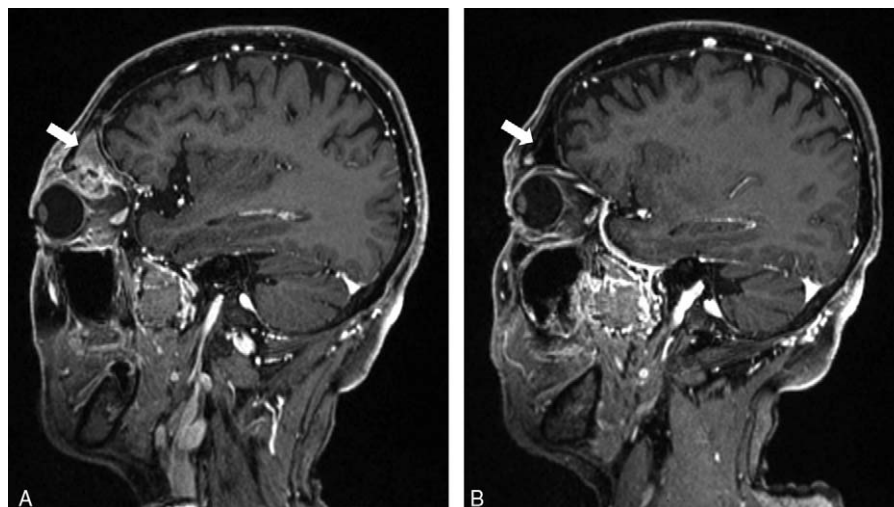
Magnetic resonance imaging of left ocular region before and after therapy. White arrows indicate the change of lesions. (A) Neoplasm and soft tissue mass in left frontal sinus before chemoradiotherapy, sagittal section; (B) lesions disappeared in left frontal sinus after chemoradiotherapy, sagittal section.
